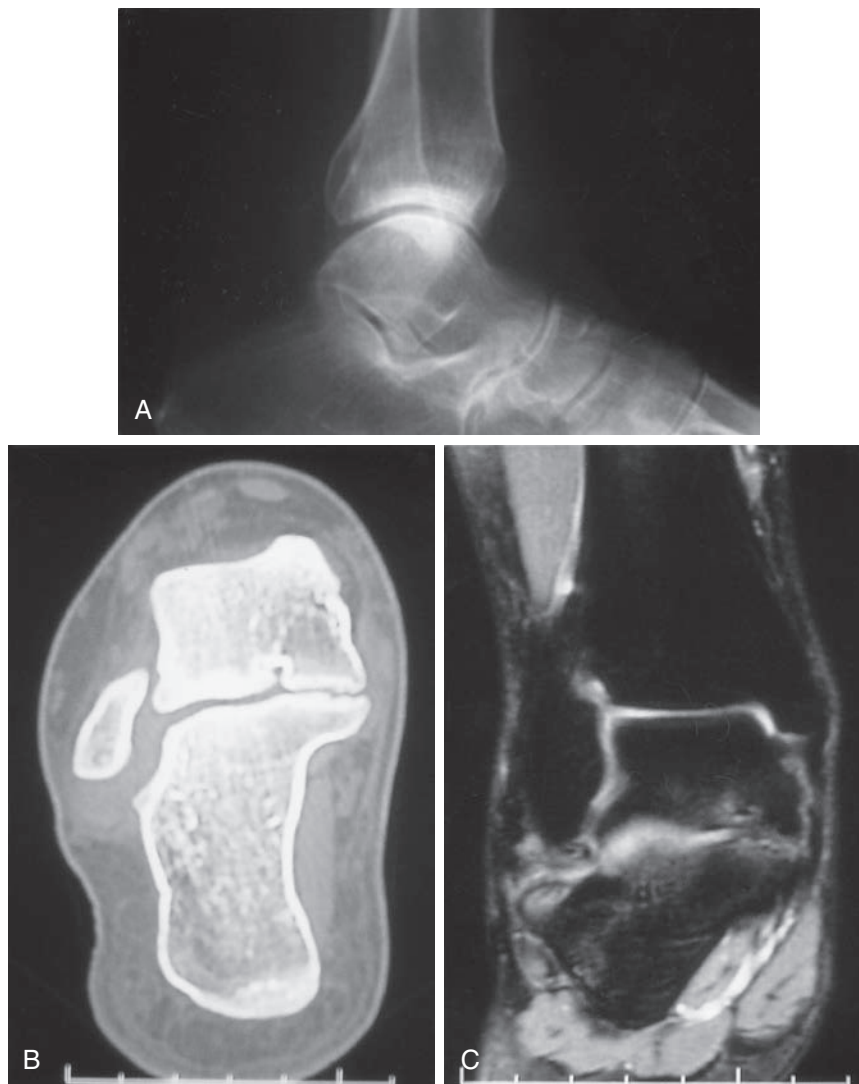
(A) Radiograph of calcaneonavicular coalition, with “anteater nose” projection from anterior process of calcaneus to navicular. (B) Computed tomography scan. (C) Magnetic resonance imaging of middle facet coalition.
